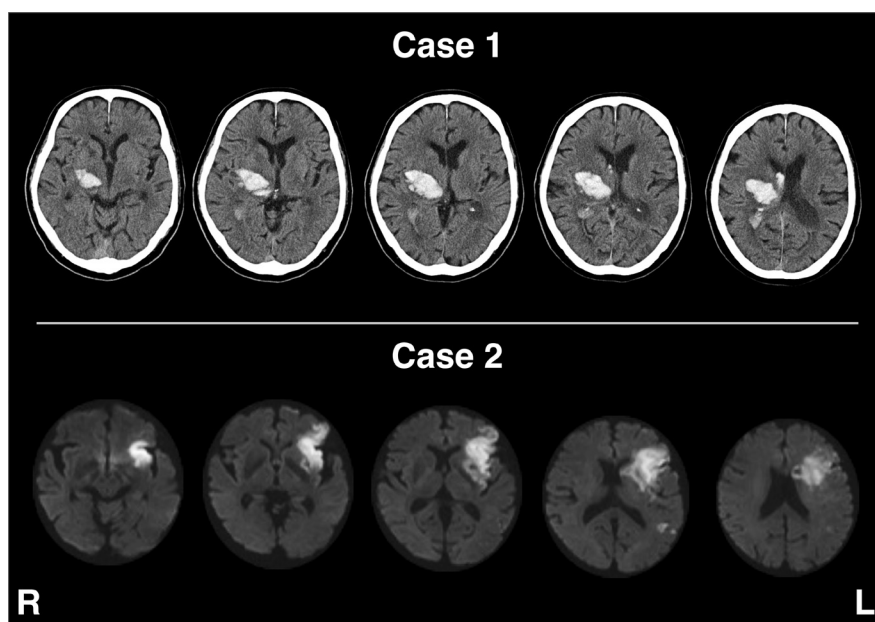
Computed tomography images (Case 1) and diffusion-weighted magnetic resonance images (Case 2) obtained during the acute stage. L: left; R: right.
